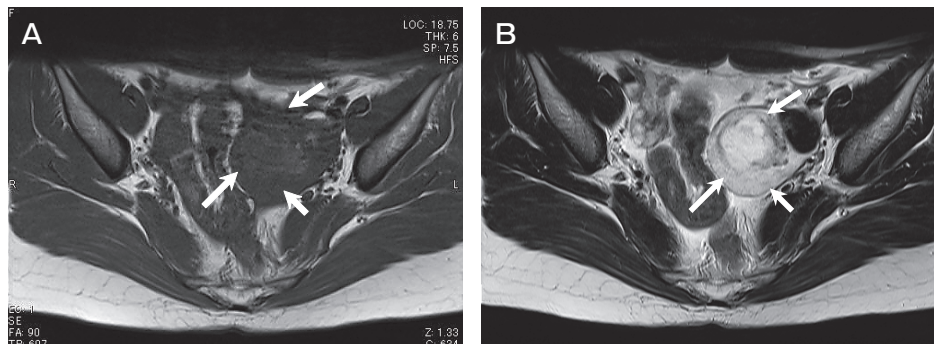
(case 3): Pelvic MRI shows the left part of the mass (6 cm) producing a low signal intensity on T1-WI A, and a very low signal intensity on T2-WI B. At the center of the mass, a high-density area is seen on the T2-WI B.
